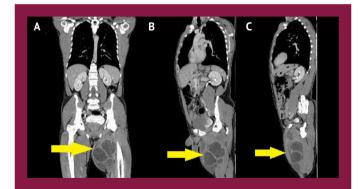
Large cystic lesion containing the small round cysts (computed tomography scan with contrast) A: Coronal, B: Oblique, C: Sagittal plane images
